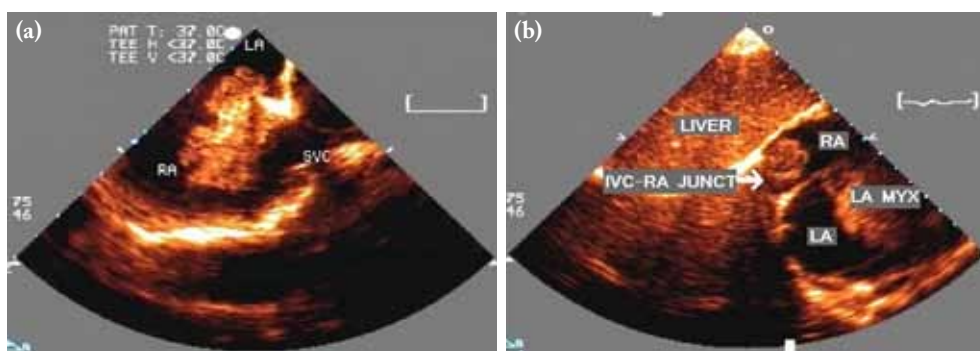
Transesophageal echocardiography images showing (a) a right atrial myxoma attached to the fossa ovalis of interatrial septum; and (b) a right atrial myxoma at inferior vena cava-right atrial junction.
